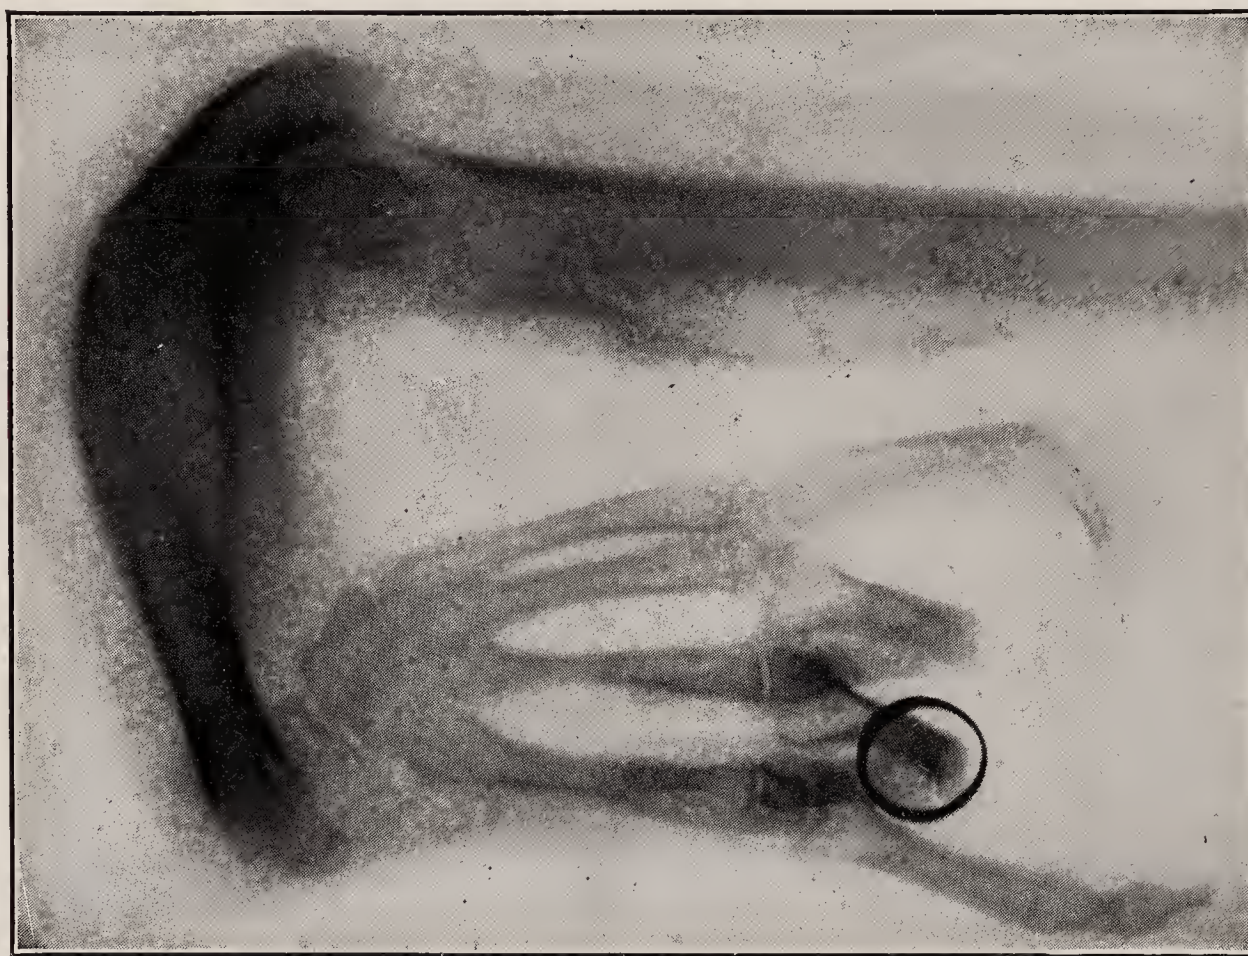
Club hand in adult—X-ray (mother of child shown in 579 and 580).
